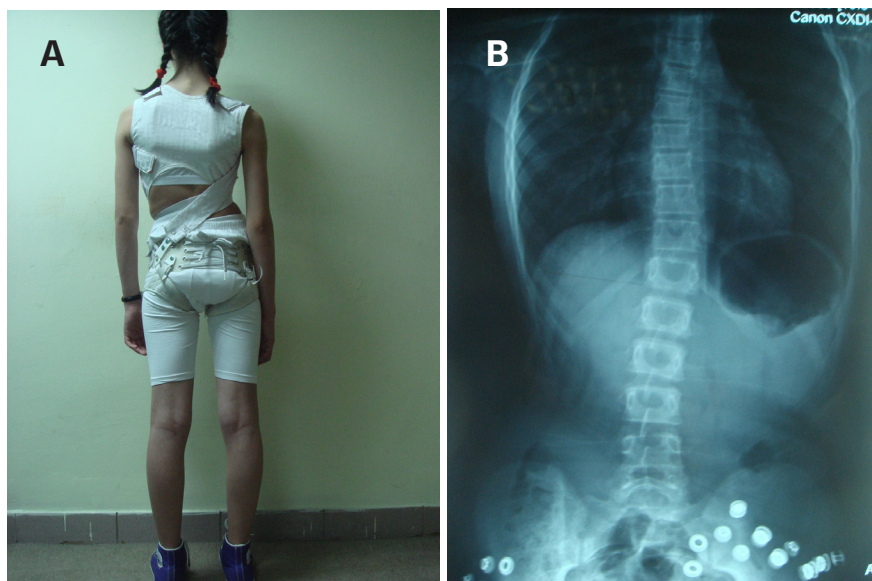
Spinecor brace (A) AP x-ray of 12 years old girl wearing spinecor brace (B)
